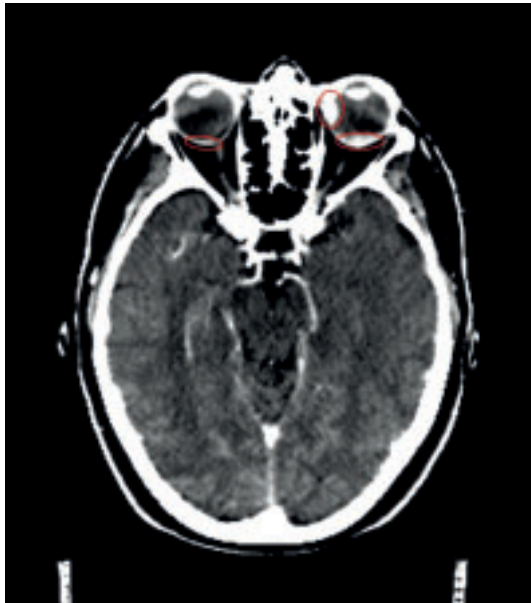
Computed tomography scan before external beam radiotherapy showing large choroidal involvement of the left eye and also the asymptomatic lesion in the right eye.
